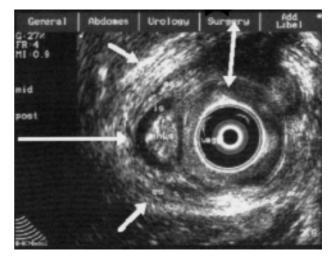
Vaginal ultrasonography in a patient with FI after laying open of anovaginal fistula. Anterior EAS defect (Long arrow points to the anal canl, small arrow points to the EAS stumps and double headed arrow points to the vagina).
